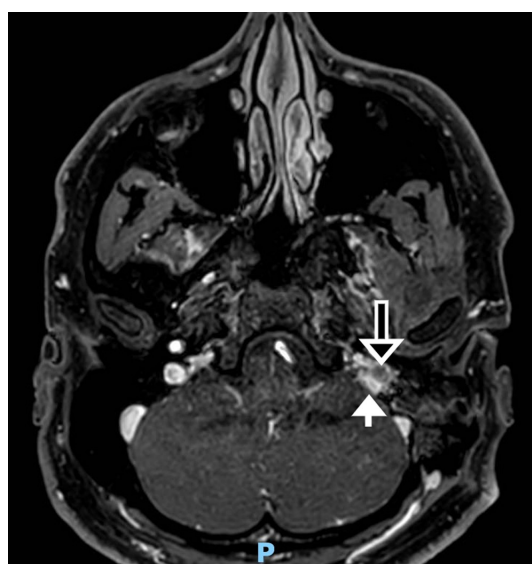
Postoperative contrast-enhanced MRI of the cerebellopontine angle. Contrast-enhanced MRI in a T1 sequence with fat suppression. The jugular vein (white arrow) is patent, and the residual tumor (black and white arrow) is shown.
